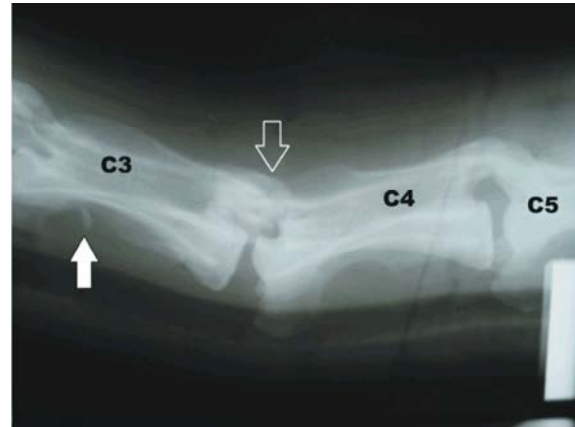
Lateral radiograph of the neck, extended position, in a llama affected by fracture of the articular facet of the fourth cervical vertebra. Note the fracture of C4 (empty arrow) and the small bone chip underneath C3 (solid arrow).
